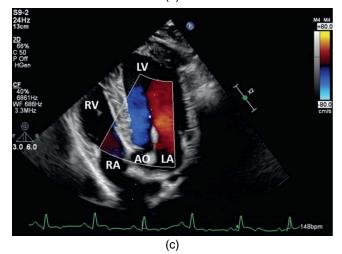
(a) Isovolumic relaxation time can be measured from apical 5 chamber views while recording aortic flow with CW Doppler. The spectral display often shows IVRT as well. If PW is used, a gate (large dot) is placed in the outflow tract between the mitral valve and interventricular septum. This will not record accurate aortic flow, of course. (b) Subcostal views can also be used. Often CW Doppler of aortic flow in this view shows IVRT on the spectral display. The time period is from the click that represents aortic valve closure to the beginning of mitral flow into the left ventricular chamber (between arrows). (c) Color flow Doppler can define the junction of red flow into the left ventricular chamber and blue flow down into the aorta. A CW Doppler cursor placed along this junction can record IVRT. If using PW, place a gate at the junction of these two flows (large dot).
